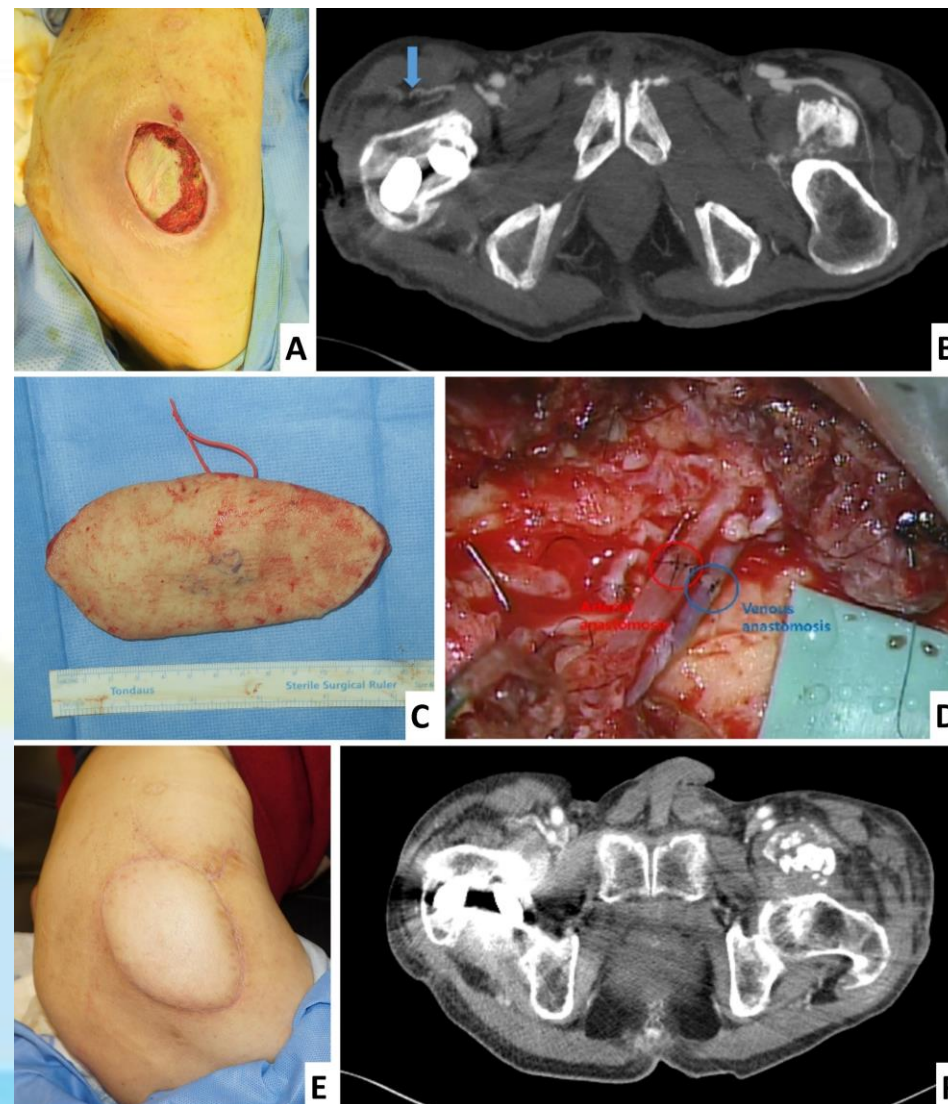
Preoperative clinical photograph: The size of the right trochanteric defect before surgery was 9 cm x 7 cm and the base was exposed to escharous muscle fascia. Figure B. Preoperative CT showed that the SCIP was dominant. Perforator is indicated by the arrow.
